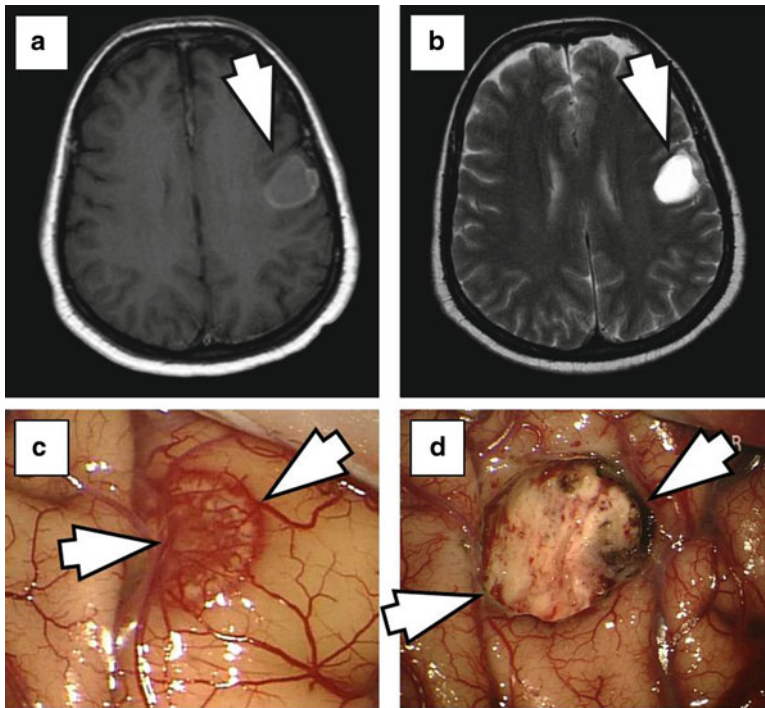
55-year old patient with known breast cancer who presented with aphasia. (a) T1-weighted MRI after contrast administration shows a cystic ring-like contrast enhancing left temporo-parietal lesion (arrow). (b) T2-weighted MRI
